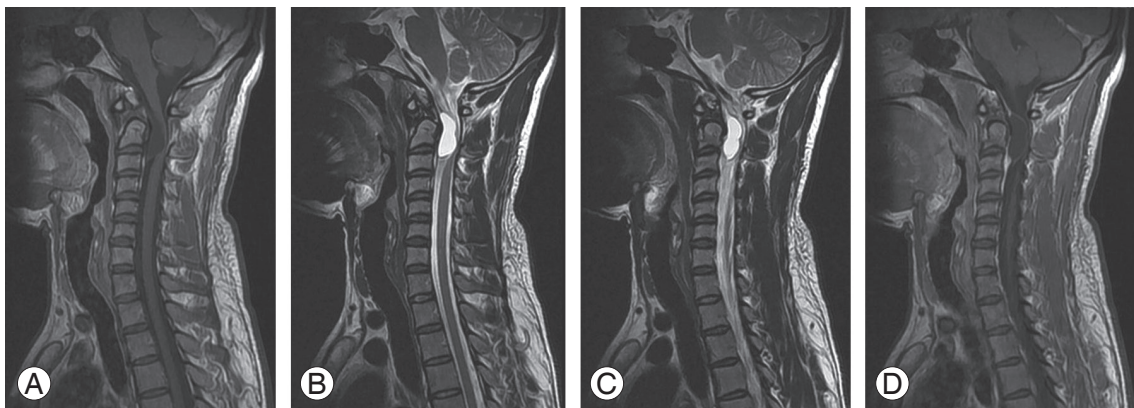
Magnetic resonance imaging cervical spine sagittal images showing an isointense lesion on the T1W image (A), becoming hyperintense on T2W (B) and fluid-attenuated inversion recovery sequence images (C), with peripheral rim of enhancement after contrast administration (D).
